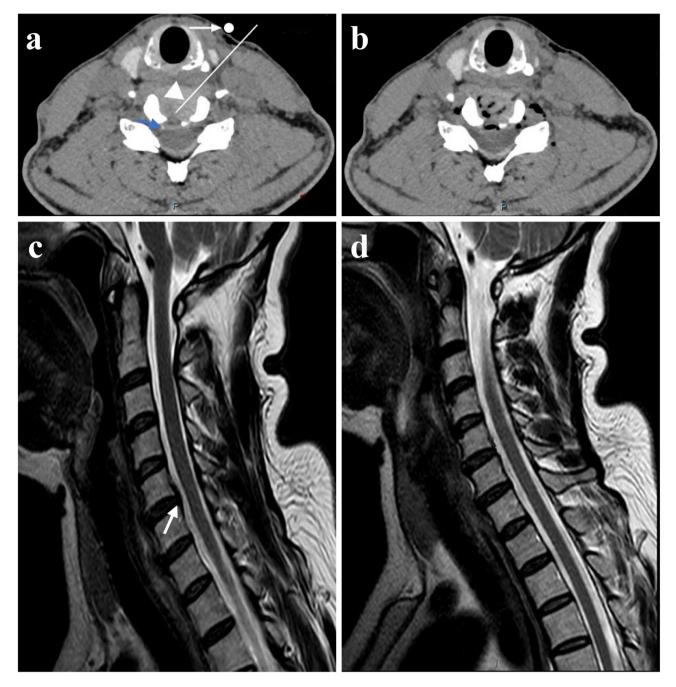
A 63-year-old female patient presented with right arm pain. Intraoperative CT scans showing a herniation (blue arrow) on the right side, surface markers (white arrow), and the designed needle route (white triangle and line) (a). Intraoperative CT scans showing volumetric reduction of the tissue of the nucleus pulposus after coalition (b). Preoperative T2-weighted MRI showed a herniation (white arrow) at the C5/6 level (c), and the herniation was disappeared oin postoperative (3 months) MRI scans (d)
